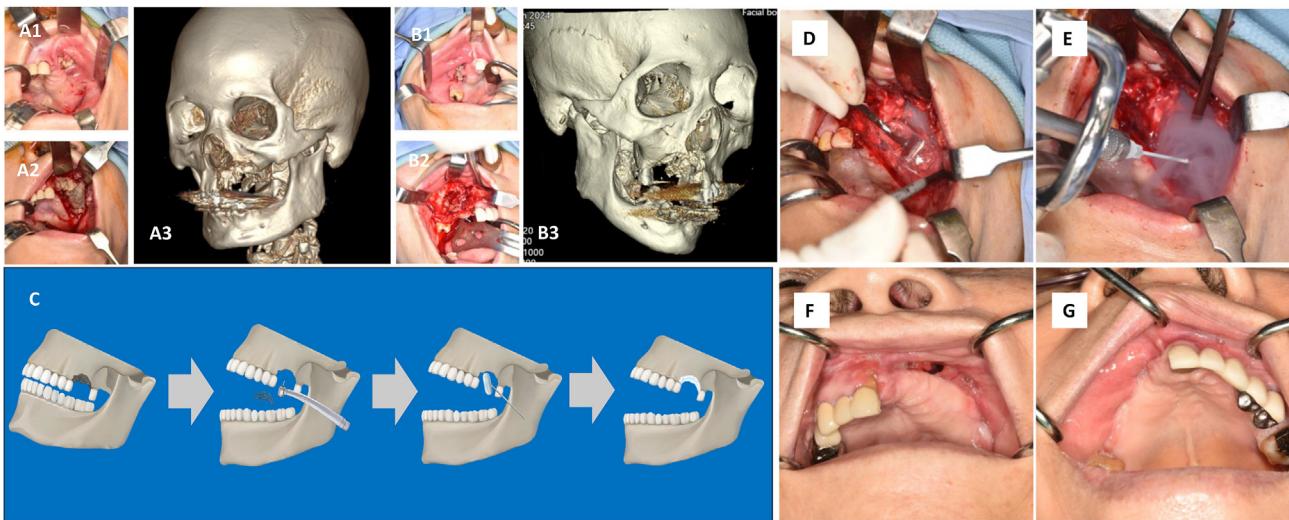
(A) A 74-year-old woman with the MRONJ of the left maxilla: (A1) Pre-operation intraoral view. (A2) The lesion was exposed during the surgery. (A3) The 3D image reconstructed from the computed tomography (CT) data of the first patient. (B) A 72-year-old female patient who had developed the MRONJ in the right maxilla: (B1) Pre-operation intraoral view. (B2) The lesion was exposed during the surgery. (B3) The 3D image reconstructed from the CT data of the second patient. (C) The procedure of the surgery: Exposure of the lesion in the first step, removal of the sequestrum in the second step, the liquid nitrogen application to the residual maxillary bone surface in the third step, and completion of the surgical procedure in the fourth step. The treatment with the liquid nitrogen gel (D) or the liquid nitrogen spray (E) after the conventional surgery to remove the sequestrum. The post-operation 6-month follow-up of the first case (F) and the second case (G) showing the complete healing of the intraoral surgical sites.
